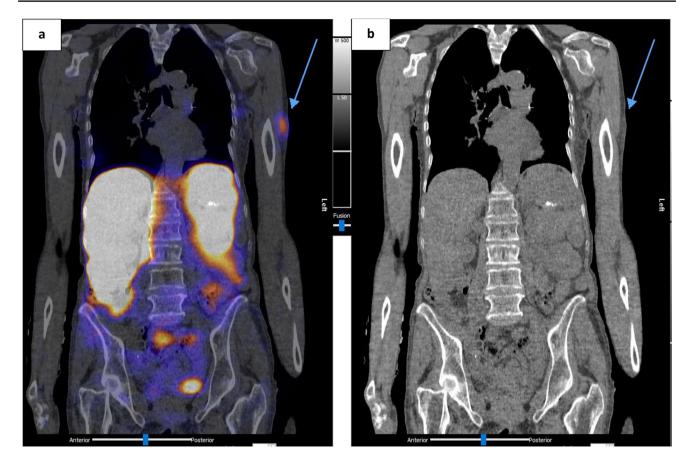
Patient A: [¹⁷⁷Lu] Lu-DOTA-TATE Cycle 3 post-therapy SPECT/CT showing. a Coronal fused SPECT/CT; b Coronal CT images. Location of the new focus of uptake is denoted with tip of blue arrow
